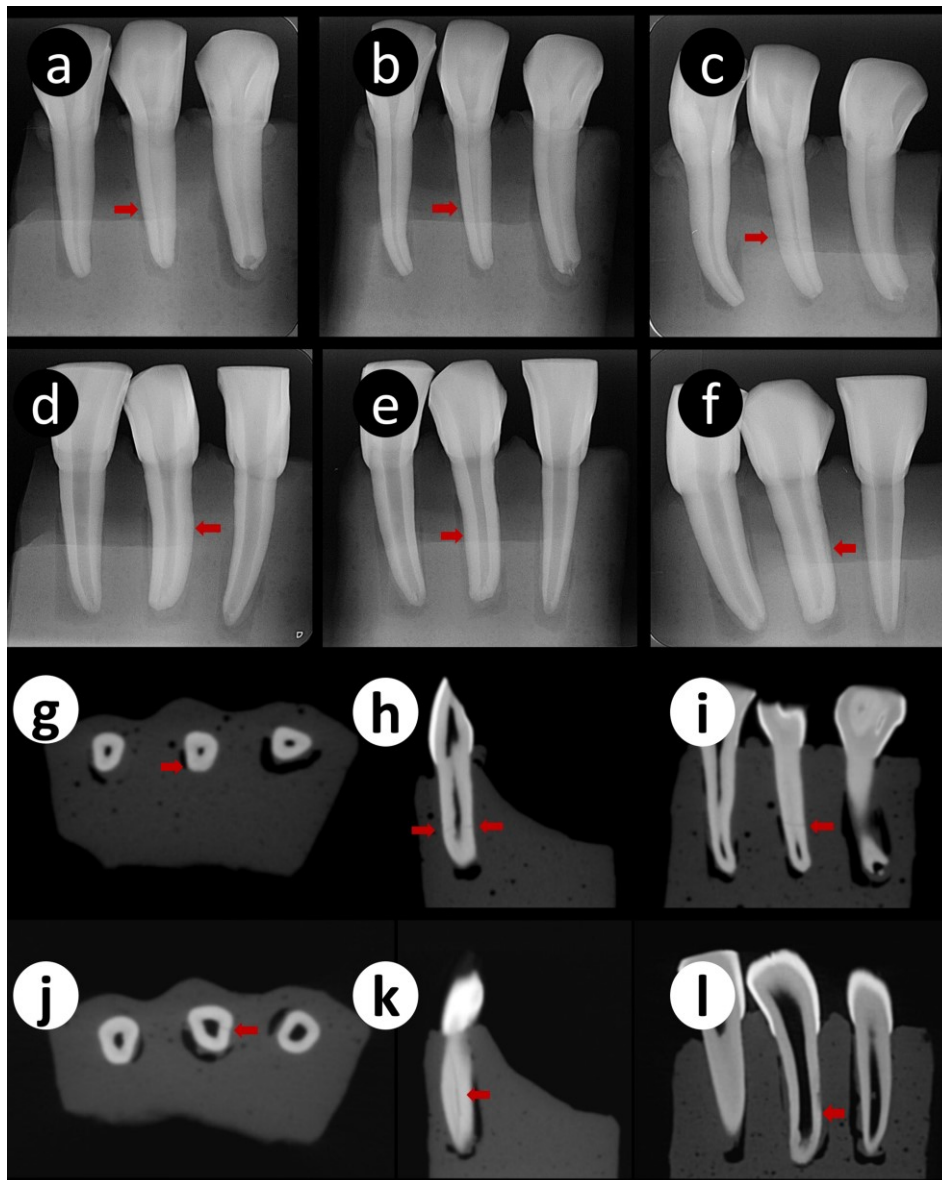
Imagens of horizontal and oblique fracture on periapical radiography (a-f) and CBCT (g-l). Periapical radiography: a- mesially; b- conventional; c- distally, indicating a horizontal fracture. Periapical radiography: d- mesially; e- conventional; f- distally, indicating an oblique fracture. CBCT images: g- axial, h- sagittal, i- coronal, indicating a horizontal fracture. CBCT images: j- axial, k- sagittal, l- coronal, indicating an oblique fracture. The red arrows indicate the fracture lines.
